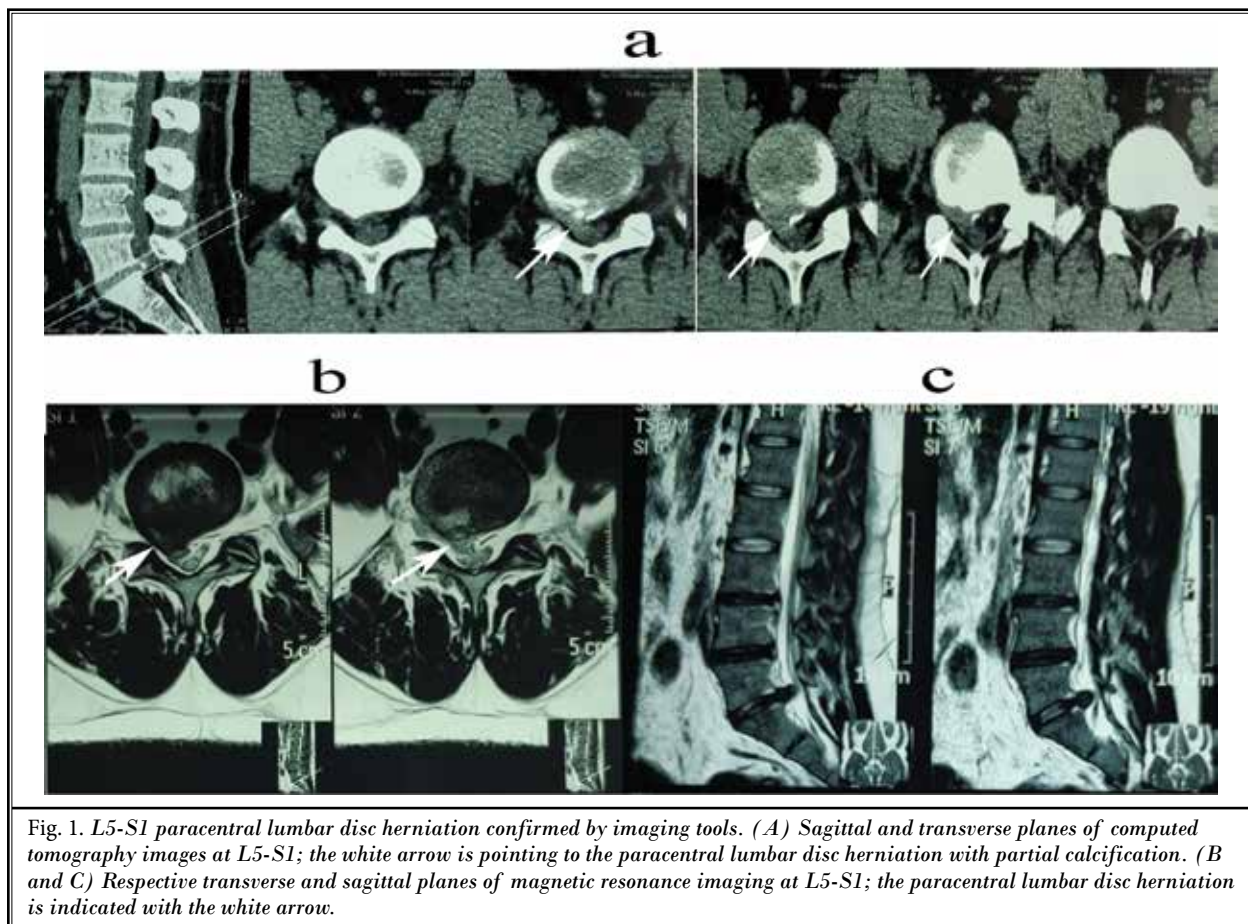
L5-S1 paracentral lumbar disc herniation confirmed by imaging tools. (A) Sagittal and transverse planes of computed tomography images at L5-S1; the white arrow is pointing to the paracentral lumbar disc herniation with partial calcification. (B and C) Respective transverse and sagittal planes of magnetic resonance imaging at L5-S1; the paracentral lumbar disc herniation is indicated with the white arrow.
